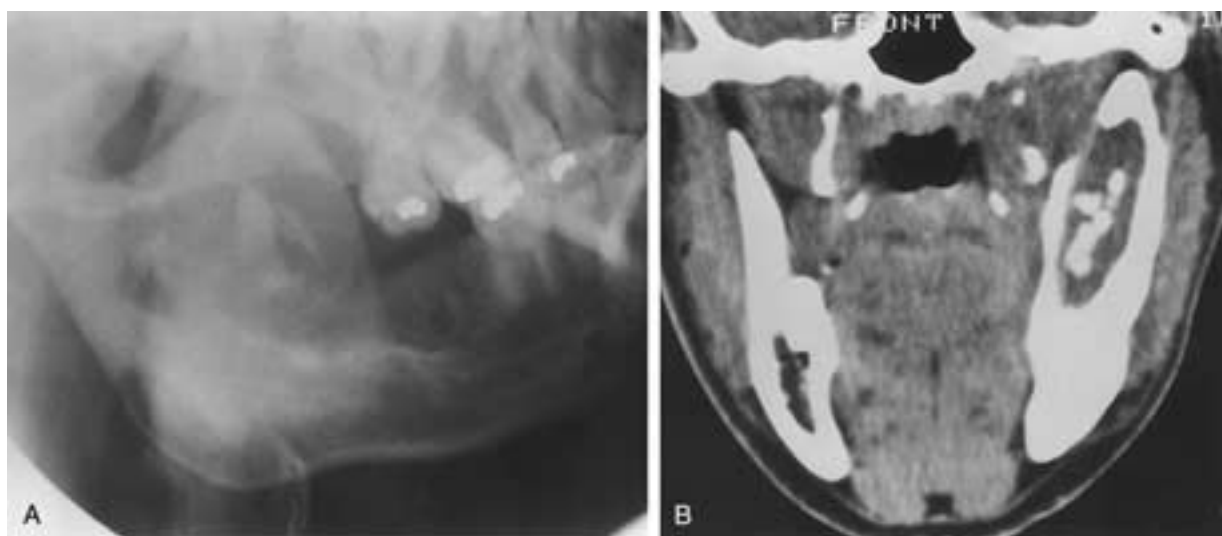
Monostotic fibrous dysplasia in the left mandible. A, Oblique view of the left mandible shows a sclerotic expansile lesion in the ramus of the mandible, with extension into the coronoid process. There are some calcific densities within the central anterior part of this lesion. B, Coronal CT (soft-tissue window setting) shows the expansile nature of the lesion in the ramus. Calcified densities are noted within the lesion.
